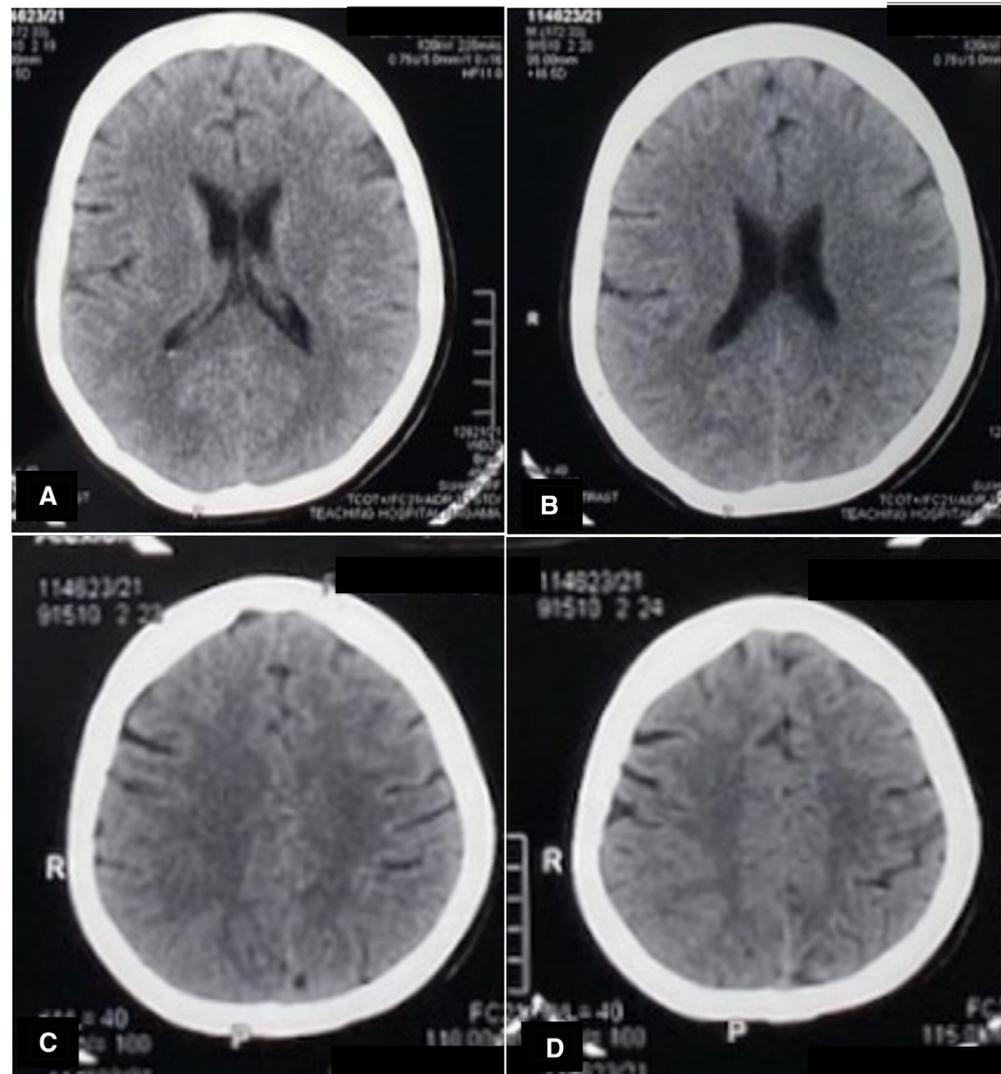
(A–D) CT scan of head without contrast (axial view) showing no evidence of acute infarction or haemorrhage.
